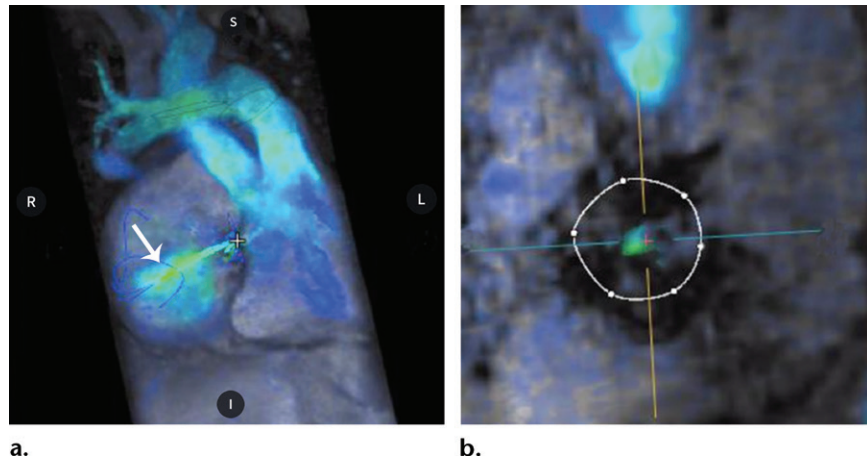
Cardiac 4D flow MRI after tricuspid bioprosthetic valve replacement. (a) Image with streamlines shows systolic central regurgitation (arrow). Artifacts are negligible, allowing assessment of tricuspid regurgitation flow, which may be difficult to achieve with echocardiography. (b) Regurgitant fraction can be assessed at the tricuspid valve level or estimated by comparing pulmonary outflow to right ventricular stroke volume.
